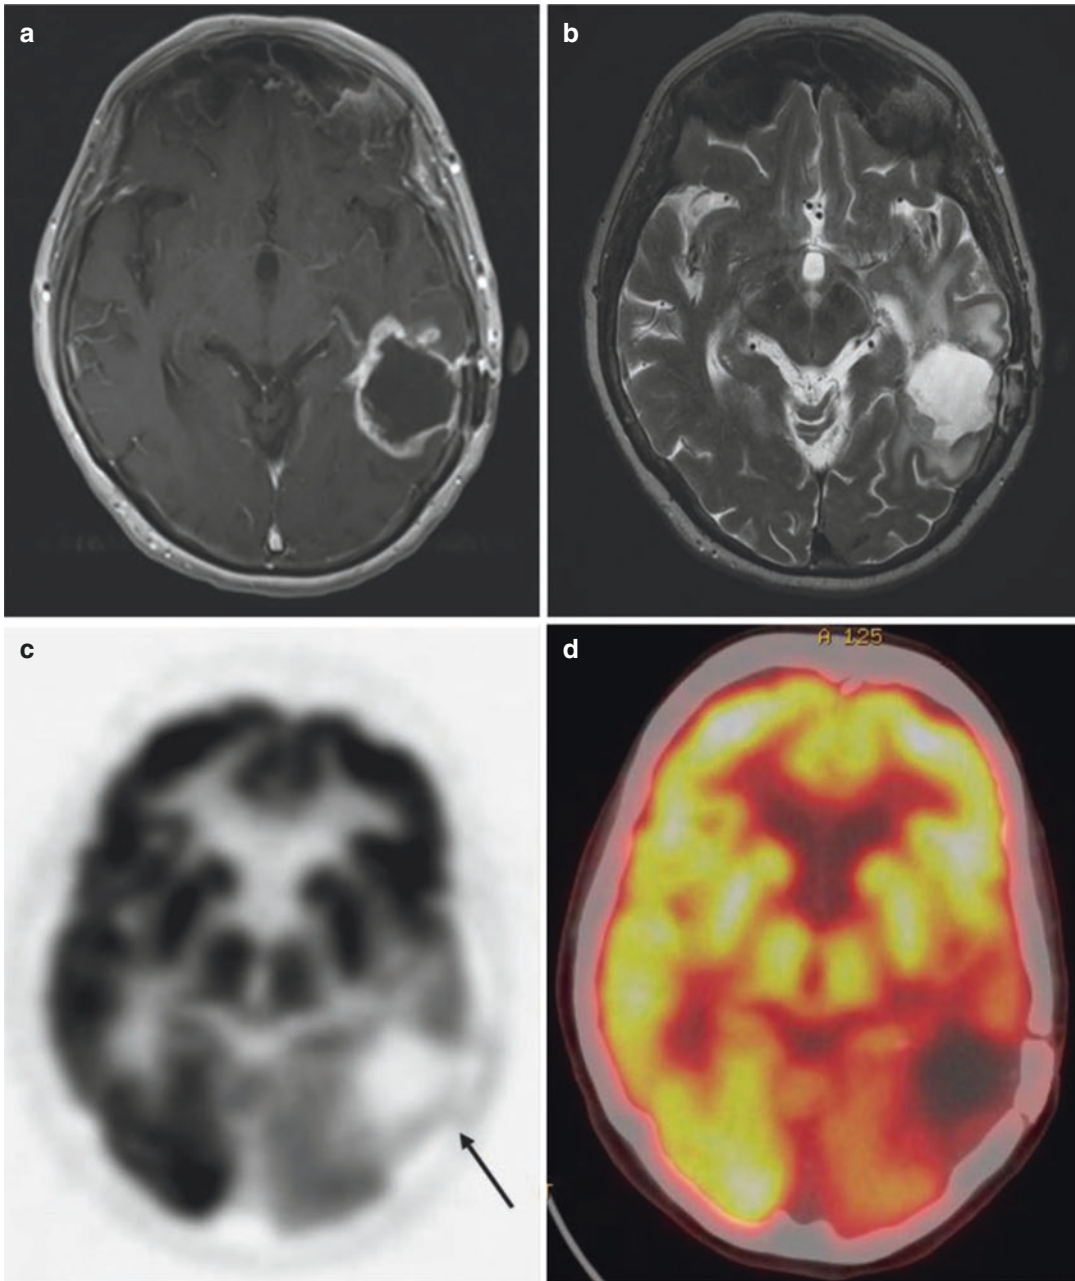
^{18}F -FDG PET for tumor recurrence: a 71-year-old male patient with history of glioblastoma multiforme, status post resection, presents for evaluation of recurrence. Contrast-enhanced MR T1 images (a) demonstrate a large cavity in the left posterotemporoparietal junction with an irregular rim of enhancement. T2-weighted images (b) demonstrate hyperintensity in the posterotemporal and parietal lobes. These findings are
